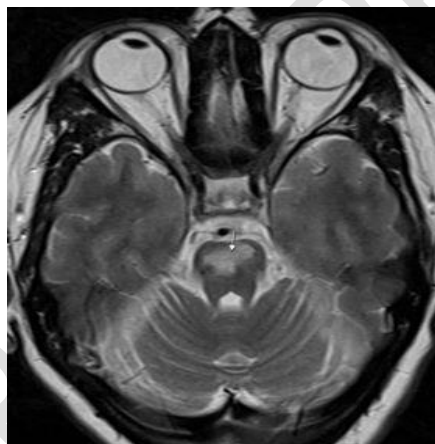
angio-MRI showing the cerebral sequelae
